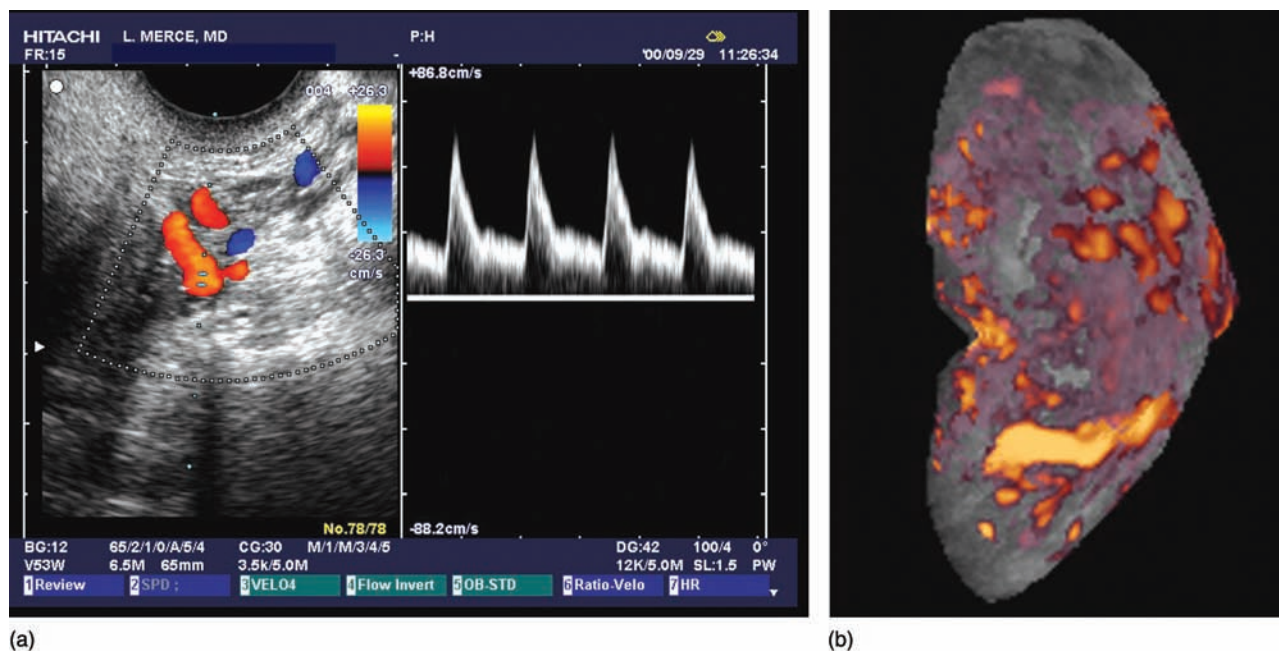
Blood flow assessment of the uterine and endometrial circulations. (a) Uterine artery FWV. (b) Three-dimensional Doppler angiography representation of the endometrial vascularity during the middle luteal phase.
